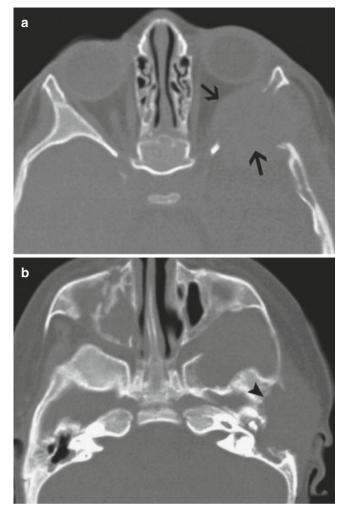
Langerhans cell histiocystosis (a) CT scan shows a lytic lesion of the frontal and sphenoid bones (*arrows*) (b) CT scan shows destruction of the temporal bone (*arrowhead*)
